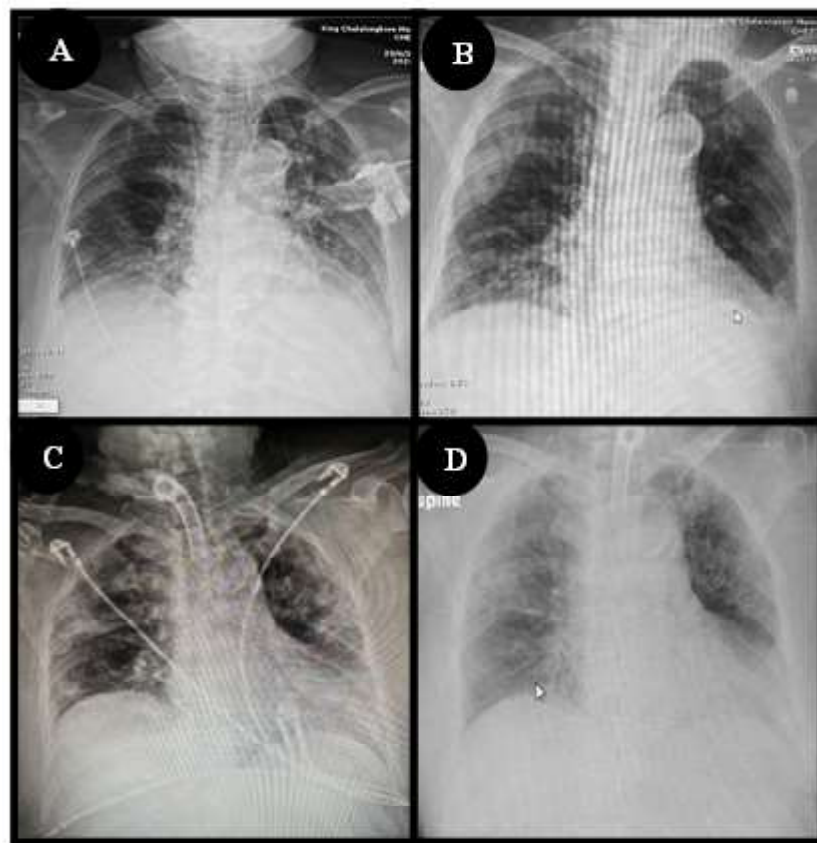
Chest radiography: (A) Diffuse patchy opacity in left lung and multifocal patchy opacities in right lung; (B) Blunting of left costophrenic angle, probably superimposed pulmonary opacity or small amount of left pleural effusion; (C) Mildly decrease in multifocal consolidation and ground glass opacities at both lungs, especially in peripheral lung zones; and (D) Mildly decrease patchy opacity in left lung and multifocal patchy opacities in right lung.
